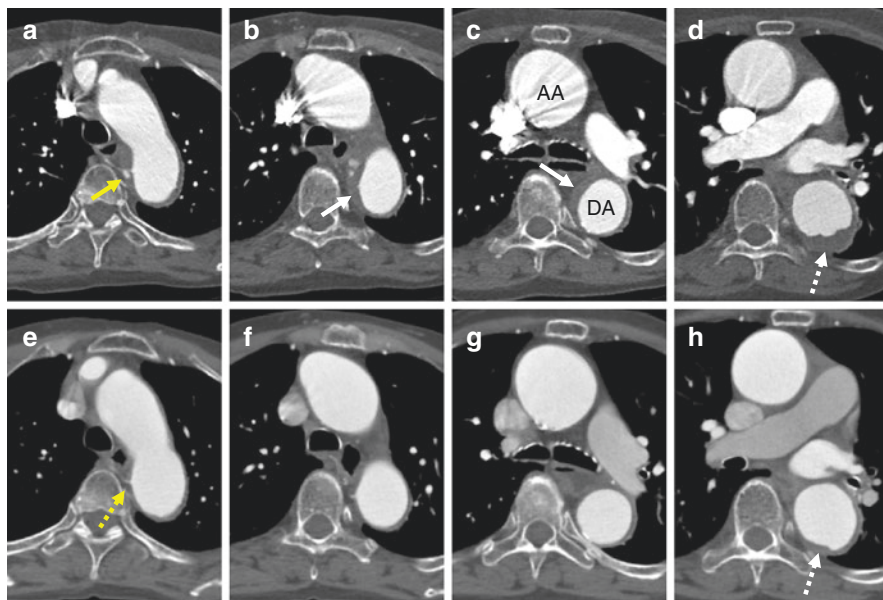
95-year old woman with chest pain and known ascending aortic (AA) aneurysm. Axial CT images with contrast (a-d) show a subtle type B IMH involving the proximal descending aorta (DA) (arrows). A small intramural blood pool associated with an intercostal artery is evident (solid yellow arrow) (a). Images from 9 months prior (e-h) confirm that the AA aneurysm is stable, but that the IMH is new. Also note the normal appearance of the intercostal artery in question (dotted yellow arrow) and the interval increase in mural atheroma (dotted arrows) which has a slightly lower density than the hemorrhage
